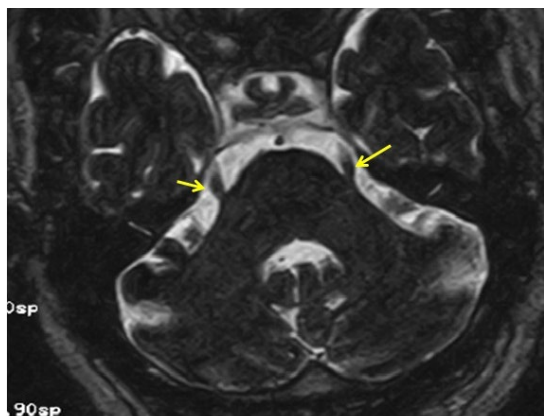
MRI aspect, axial sequence 3DT2 showing a normal nerve V (yellow arrow).
